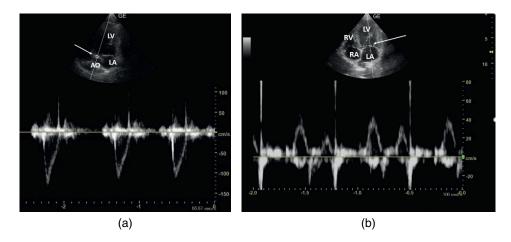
(a) A Doppler cursor placed in the aorta on an apical 5 chamber plane records blood flow moving away from the transducer, and the spectral waveform is displayed below the baseline which represents zero velocity. The pulsed wave (PW) gate here (small equal sign) is placed at the aortic valve, and the spectral flow profile is very specific for that location. (b) A Doppler cursor placed at the mitral leaflets on an apical 4 chamber plane records blood flow moving toward the transducer, and the spectral waveform will be displayed above the baseline which represents zero velocity. The PW gate here (small equal sign) is placed at the tips of the mitral valve leaflets, and the flow is very specific for that location.
